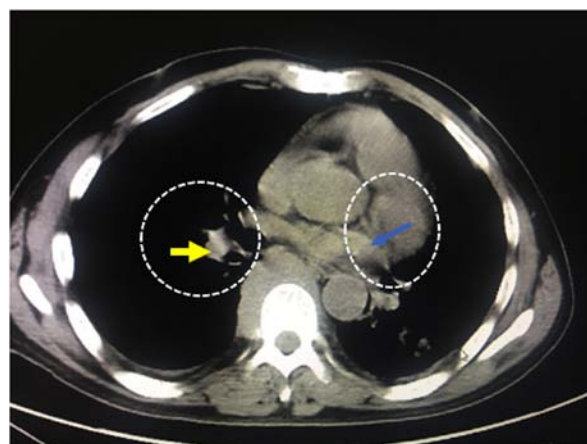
Representative scan of a 52-year-old male patient with leukemia presenting with paravertebral extramedullary hemopoiesis using chest CT (mediastinal window; an axial view of the chest with emphasis on the mediastinum). Homogeneous masses, with iso dense/iso attenuating soft parts can be observed (blue arrow). CT reveals a small right paravertebral soft tissue mass (yellow arrow). CT, computed tomography.
